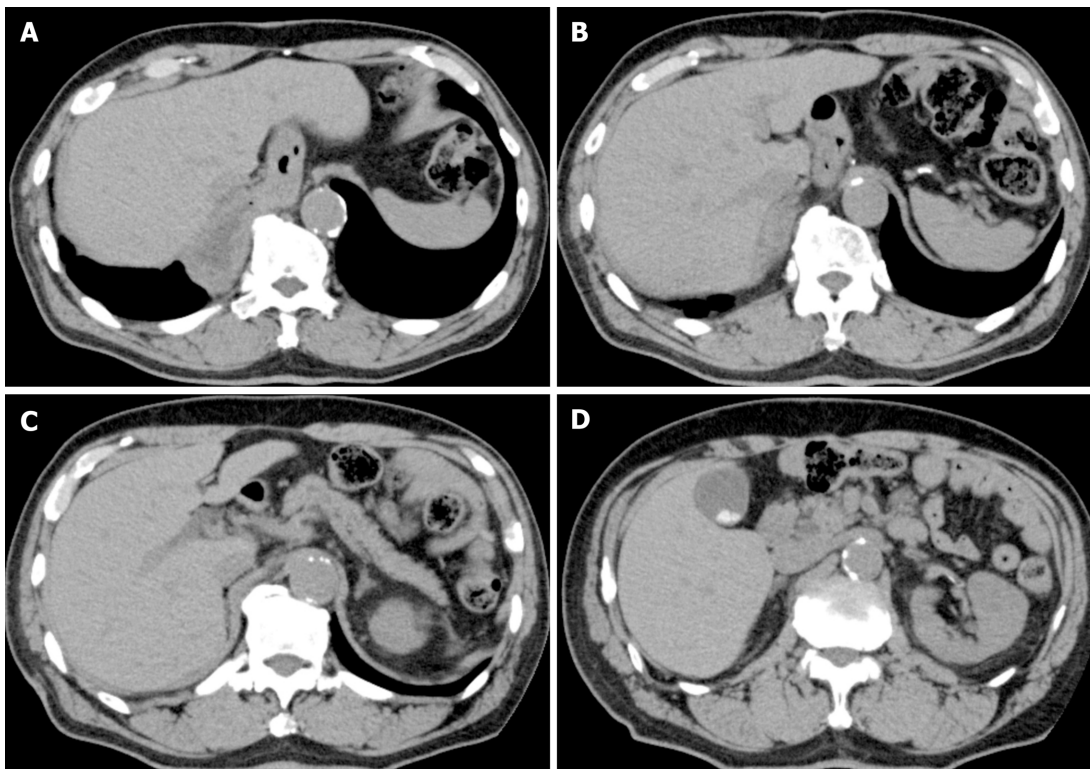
Computed tomography findings. A-D: Computed tomography was unable to detect the primary tumor, and no obvious nodal metastasis was observed.
